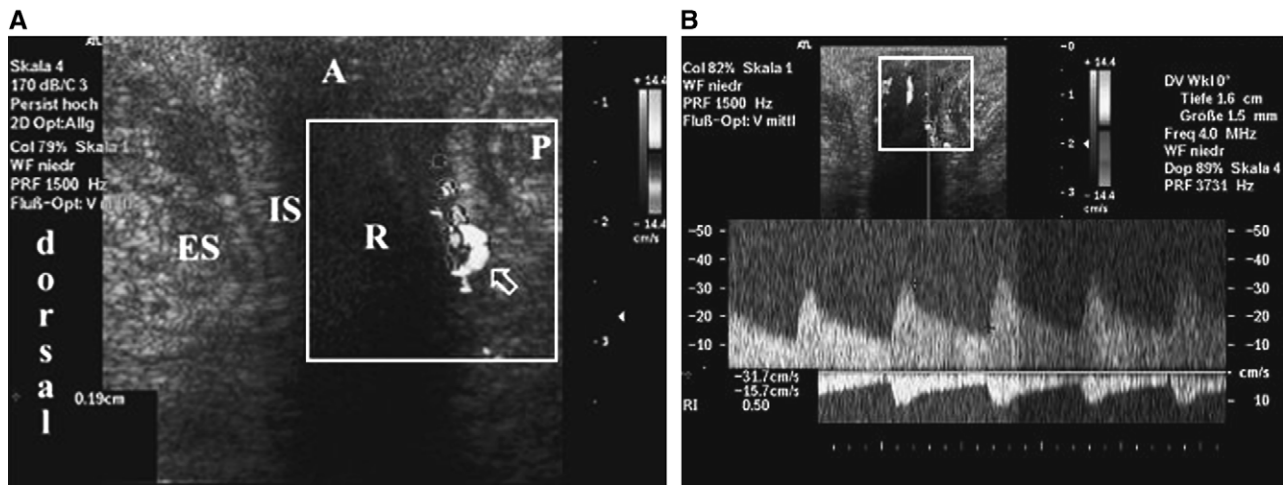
A 33-year-old male patient with hemorrhoids, Goligher grade II³; transperineal color Doppler ultrasound, longitudinal scan. (A) A dilated terminal branch of the SRA (*open arrow*, caliber 1.9 mm) is shown within the rectal submucosa connecting to the CCR (dark grey colored vascular signals). A, anal canal; R, rectum; P, prostate; IS, internal anal sphincter; ES, external anal sphincter. (B) Same patient and arterial vessel within the ventral rectal wall. Doppler measurement of the arterial blood flow (31.7 cm/second).
